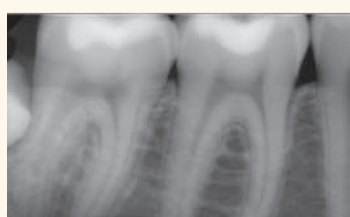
X-Ray of the final restorations. The material shows an excellent radiopacity and adaptation to the cavity walls
